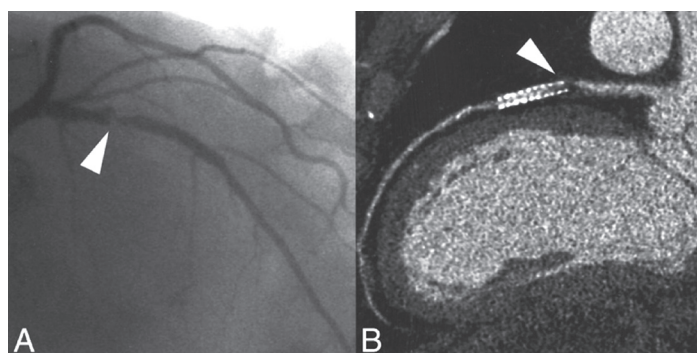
Example of a Patent Stent. Conventional coronary angiography (A) showed patency of a stent (Cypher, 3.0 x 18 mm) placed in the left circumflex coronary artery. (B and C) Two orthogonal curved multiplanar reconstructions obtained with 64-slice MSCT (Siemens Sensation, kernel B46f) are provided, also showing patency of the stent. MSCT = multislice computed tomography.
